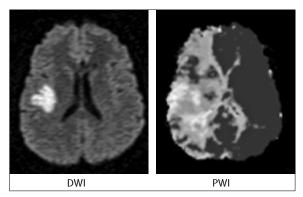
MRI of the ischaemic penumbra
